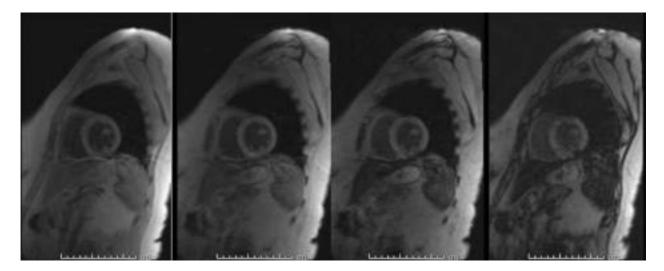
MRI 1.5 T (Siemens Avanto), using multi-TE gradient echo T2* MRI technique. Heart intensity is normal seen with the longest TE (14.68 msec). T2* =29.4 ms corresponding to <1.2 mg Iron/ g heart dry weight.
